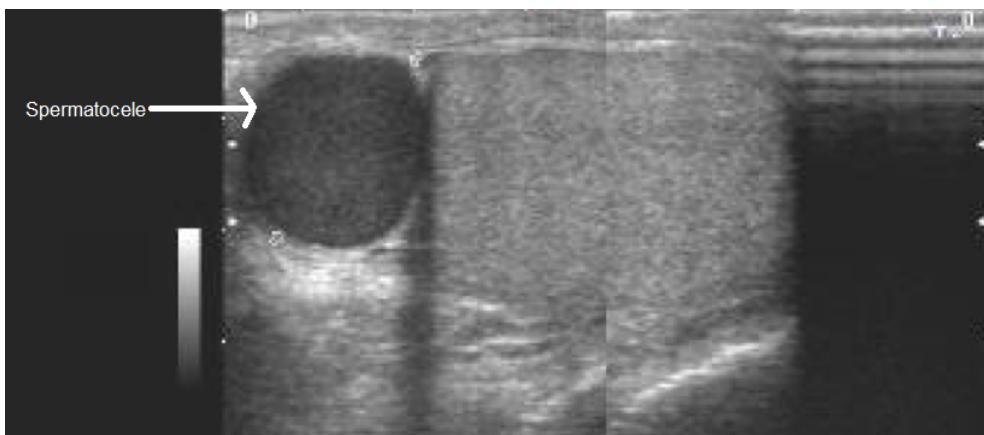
Spermatocele. Spermatoceles are distinguished on ultrasound by a hypoechoic appearance with the presence debris inside it borders. It is picture here (dark grey structure on left) next to the adjacent testicle.
